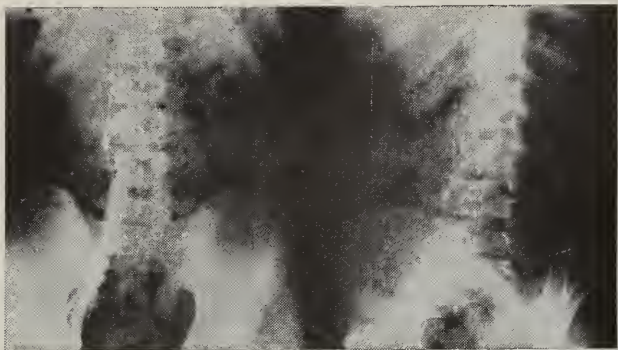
Antero-posterior and right oblique roentgenograms of the abdomen show normal appearing lymphatics and nodes in a patient whose right testis contained a small seminoma. Irradiation was given to the regional lymph nodes, including the contralateral para-aortic nodes.
